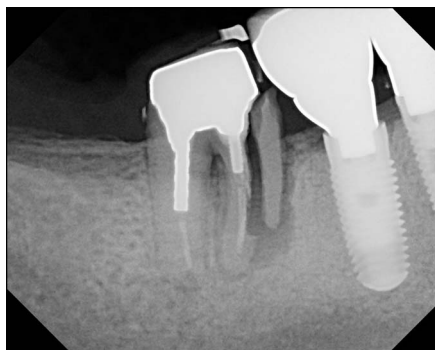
Subject 1: Periapical radiograph of a failing mandibular right second molar treatment planned for extraction and restoration with a single implant fixture. Note the fracture of the mesial root.
